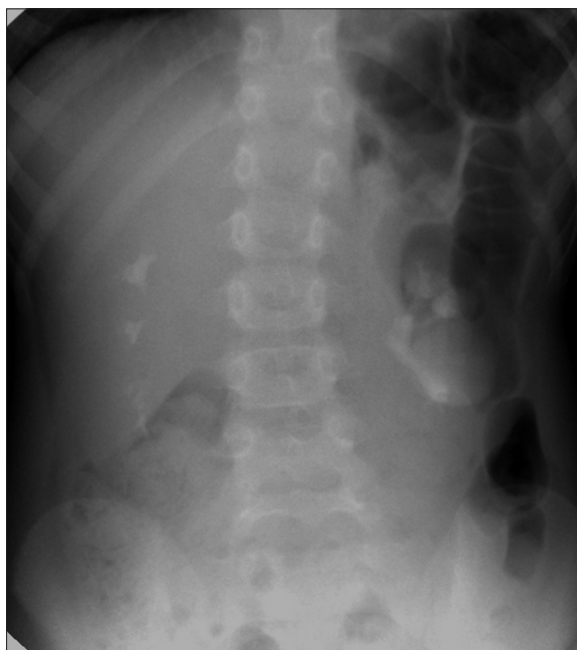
Abdominal x-ray, performed 1.5 hours after CT urography, revealed contrast retention within the cyst.
